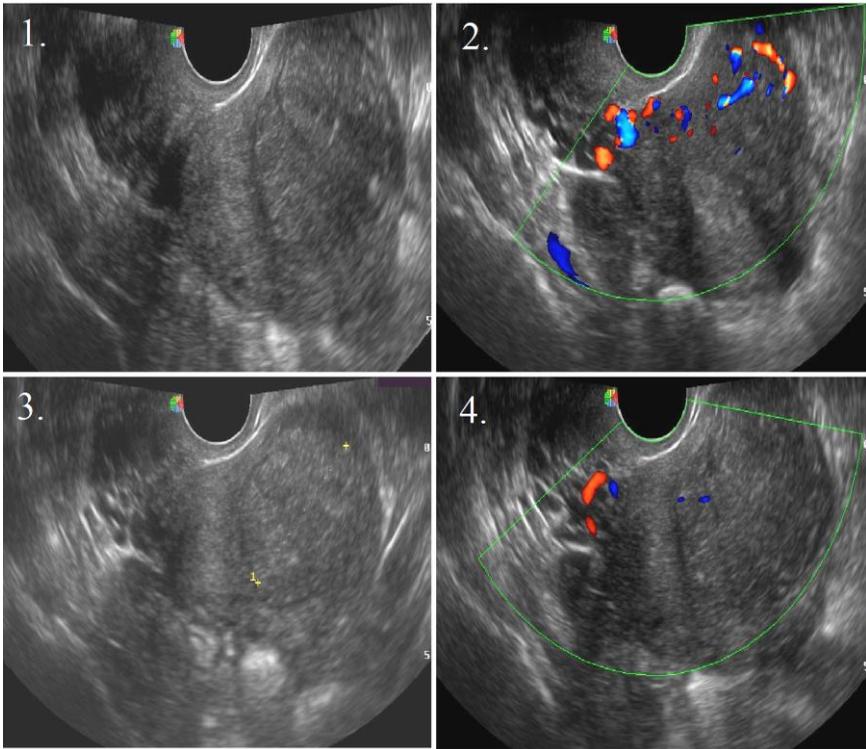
Echographic examination at one month after the intervention; discrete reduction in size(1)Lack of Doppler signal inside the nodule; normal blood flow in the myometrium(2) Three months echographical exam- dimensional reduction of the fibroma(3); 6 months endovaginal echography – absence of Doppler signal inside the fibroma(4)
